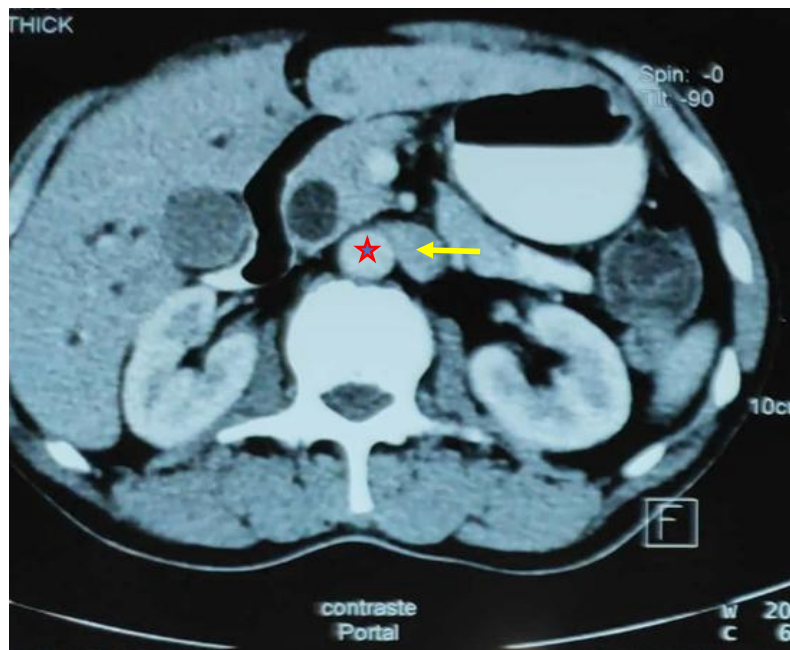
Cross-sectional CT scan showing the left position of the inferior vena cava; abdominal aorta (star), inferior vena cava (arrow)
